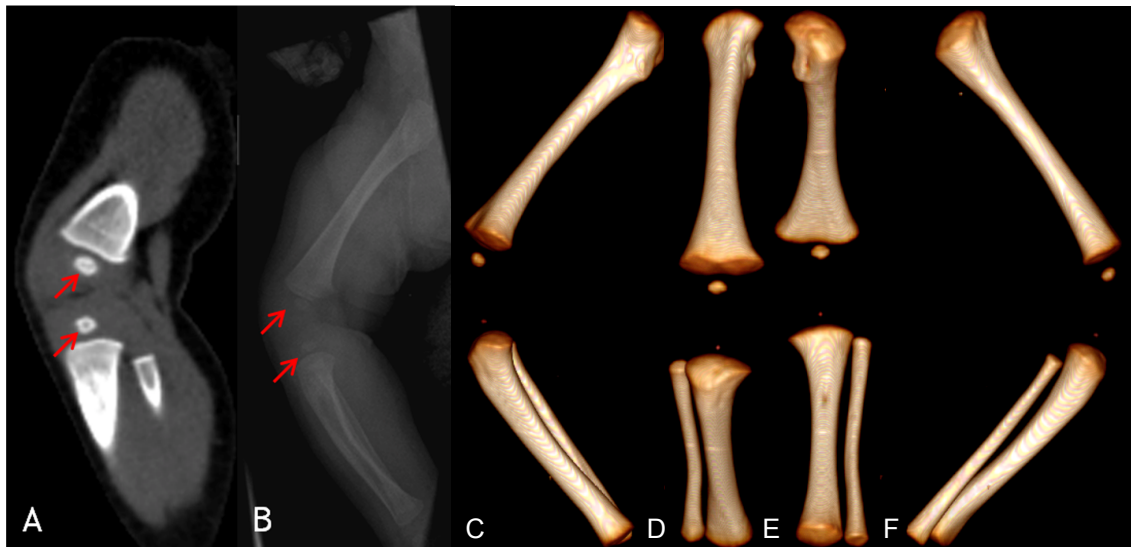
Presence of ossification nuclei; PMCT reconstructions of the lower limb. A) PMCT reconstruction; ossification sites can be seen clearly. B) X-ray image; ossification centres are visible, but not as clear as on PMCT. C-F) Lateral, anterior and posterior 3D views; ossification centres are well defined and clearly delineated.
